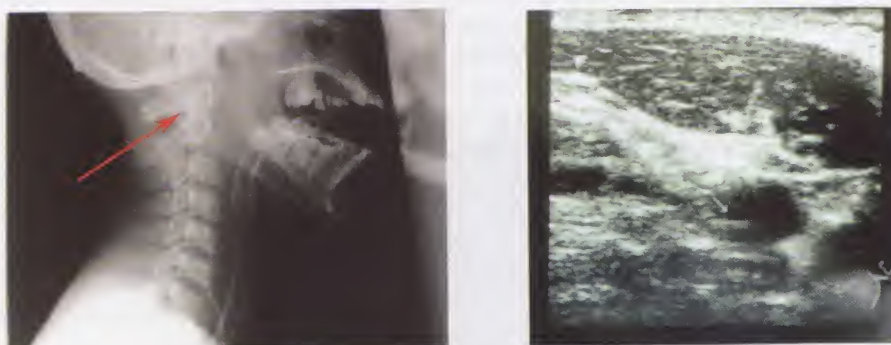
The left image is a plain x-ray lateral view neck and the right image is a transverse ultrasound image of the neck showing a fiberoptic oxymetric catheter (arrows) placed in the bulb of the jugular vein.
